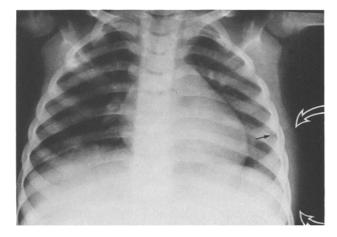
Case 4. Chest radiograph. Soft tissue swelling at the left lateral chest wall (curved arrows), and minimal adjacent pleural thickening (arrow)
